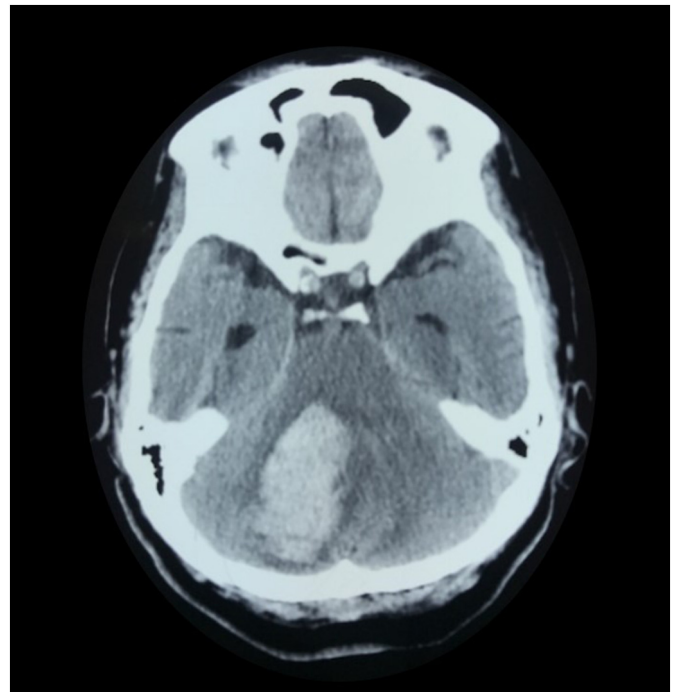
A head CT scan on admission shows a right cerebellar hemorrhage 6 cm in diameter.
